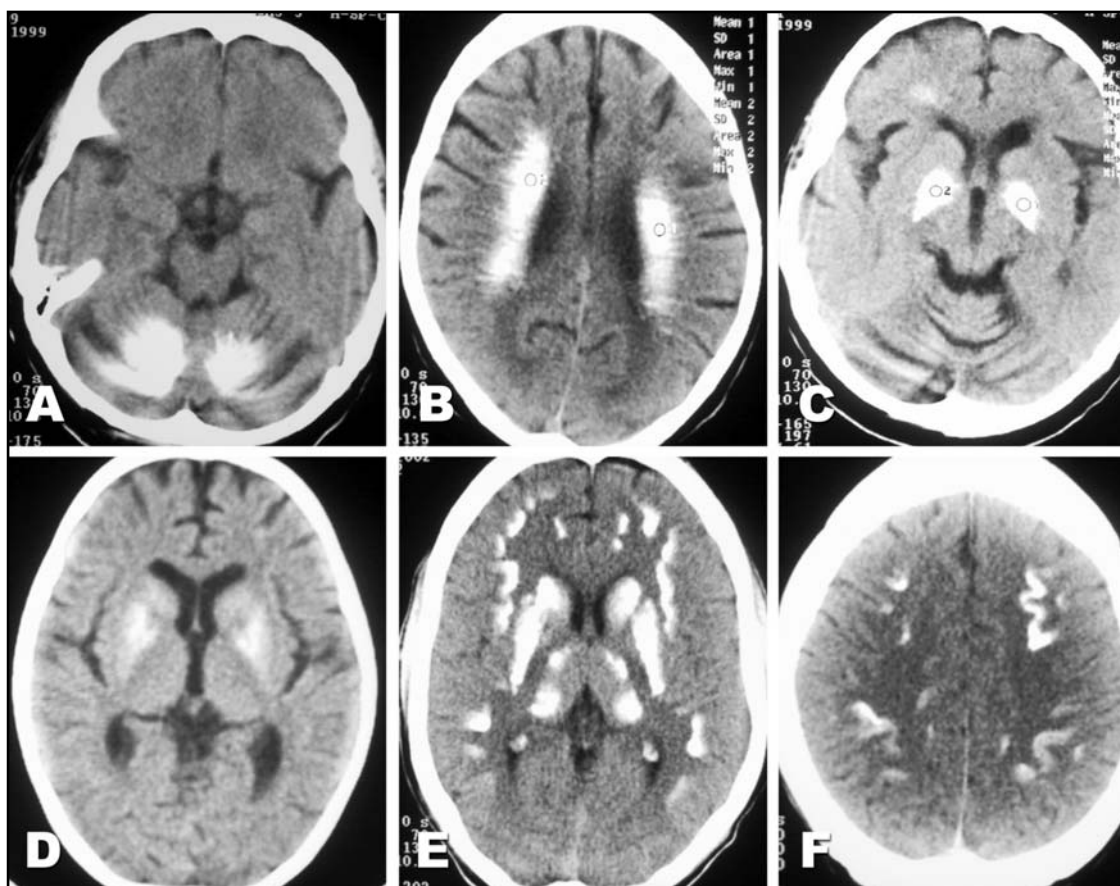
CT axial images show calcifications dentate nucleus and white matter of cerebellum (A), semioval center (B) and globus pallidus (C) in 65 years old with senile dystrophic calcifications. Basal ganglia calcification (D) is found in a patient with AIDS. Diffuse calcification in basal ganglia (E) and subcortical region (E and F) is shown in patients with hipoparathyroidism and hypopituitarism, respectively.
